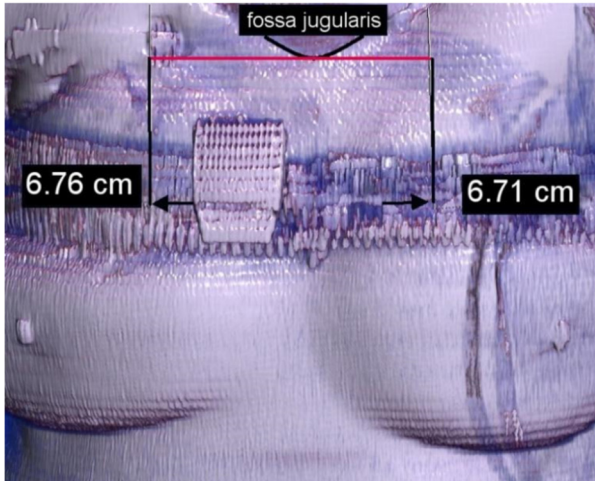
CT reconstruction of the body with distance to the skin markers.
